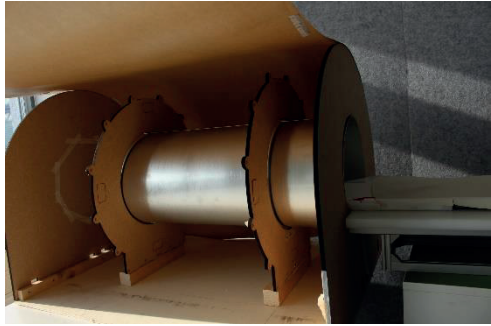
Mockup of MRI scanner
